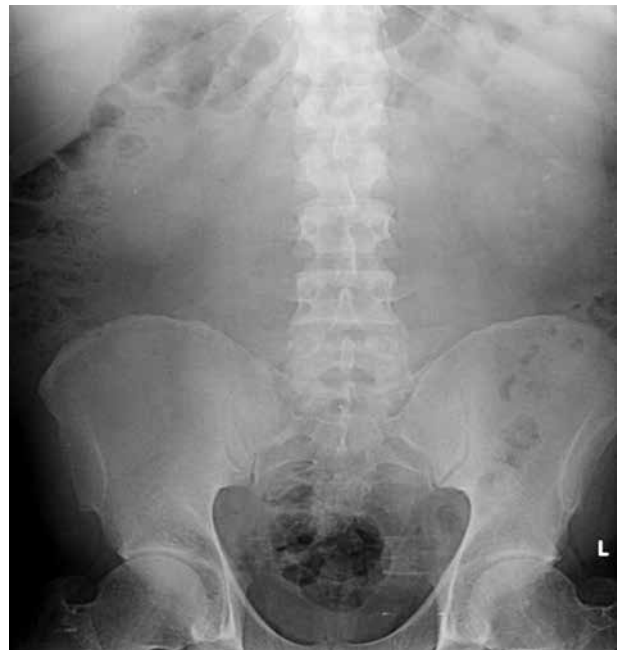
X-ray of abdomen showing radio-opaque deposits in pelvis
